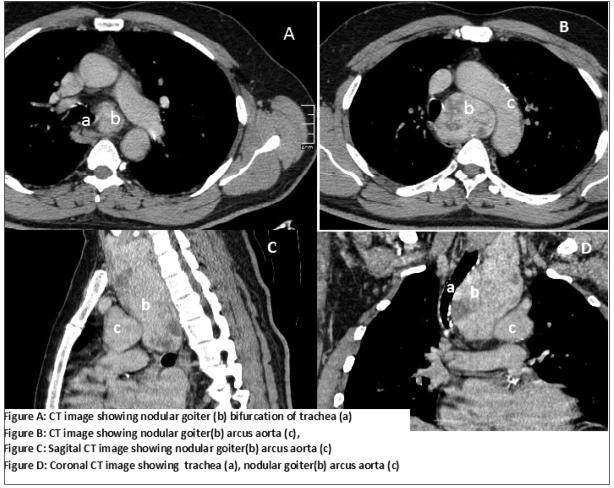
CT-scan of the patient, showing mediastinal goiter and its relationship with the mediastinal organs.
